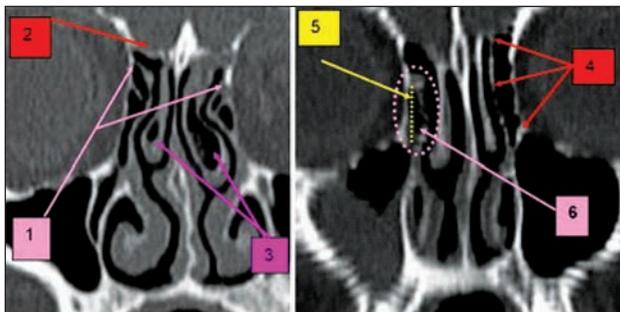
Paranasal sinuses CT scan: 1. bilateral uncinatoprocess insertion into lamina papyracea; 2. skull base; 3. bilateral concha bullosa; 4. left uncinatoprocess inserted on skull base, adherent to lamina papyracea; 5. lamina papyracea; 6. right uncinatoprocess insertion on lamina papyracea
